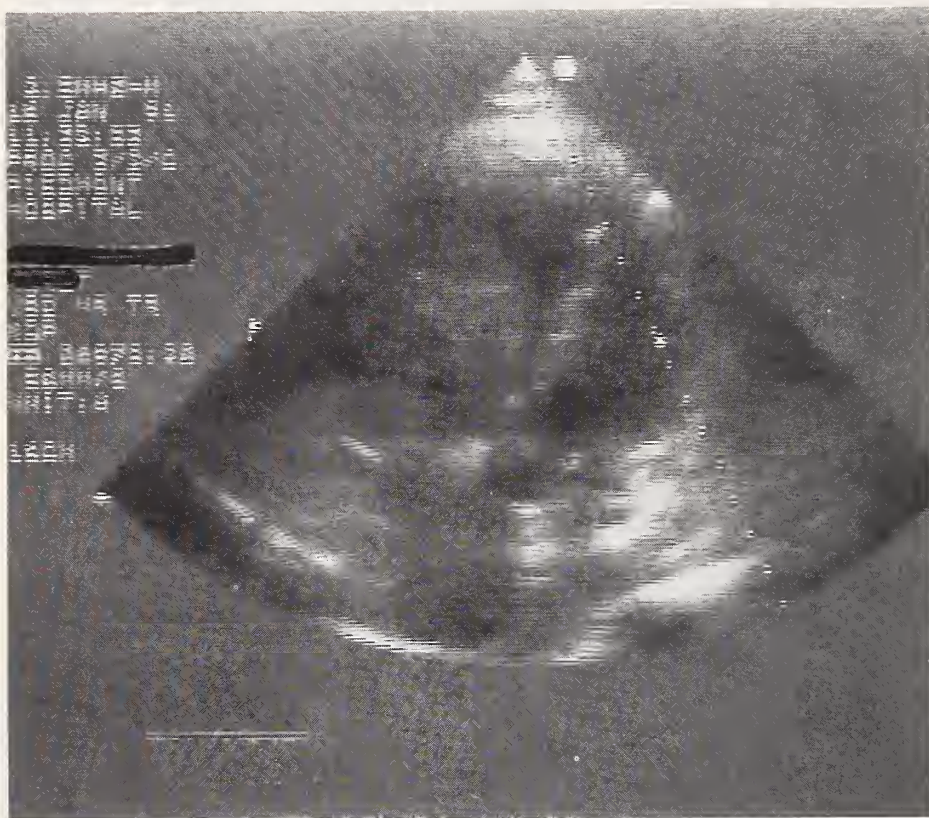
Two-dimensional echocardiogram showing right and left ventricles, interventricular septum, and mass within the right ventricular cavity.
